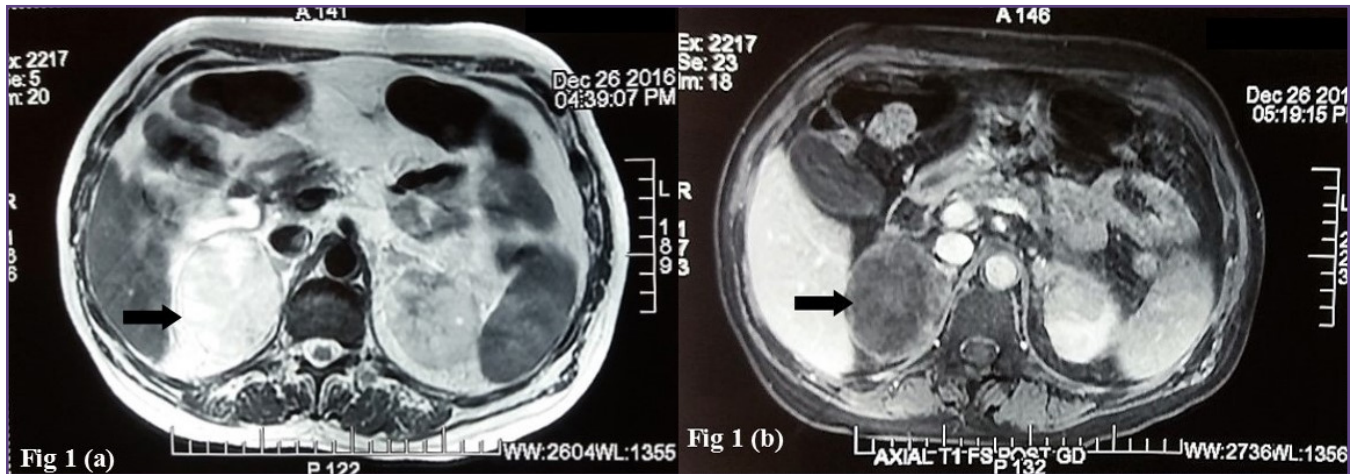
(a) : MRI features of myelolipoma - hyperintense mass (arrow) in right suprarenal in T1 image; (b): MRI features of myelolipoma - Loss of signal intensity in the lesion (arrow)with fat suppression on T1 MRI.
